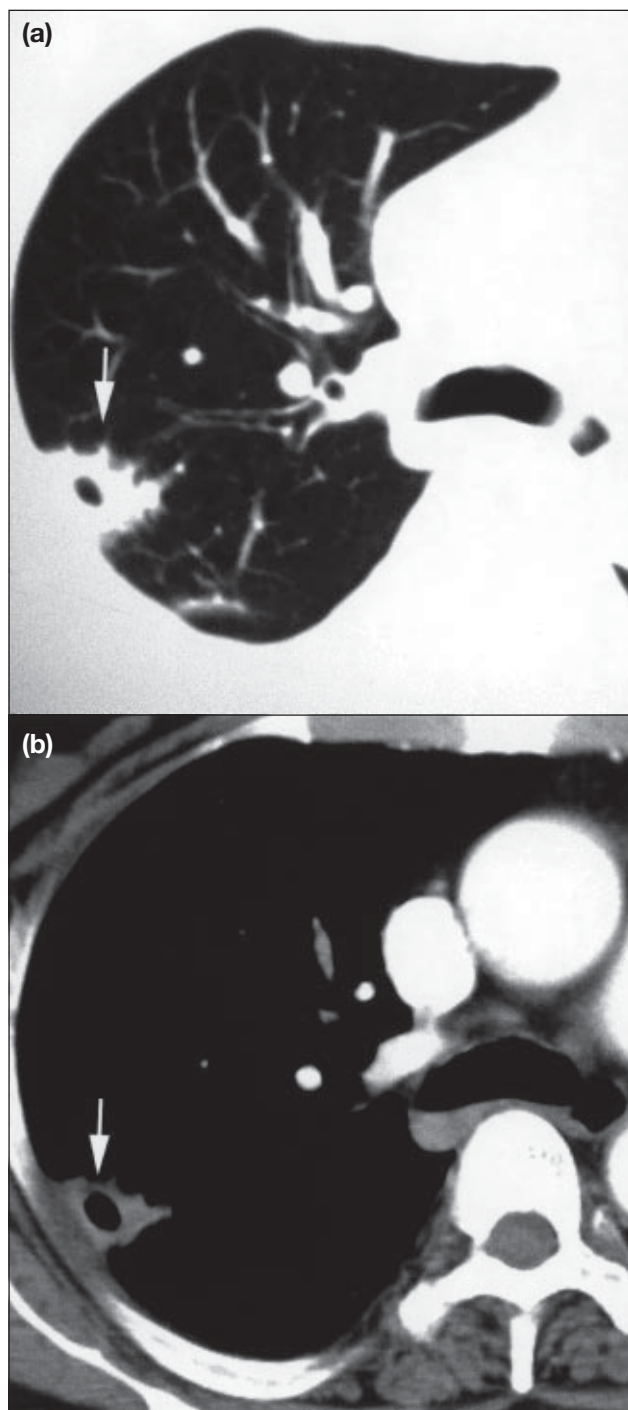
Computed tomograms showing a cavitating mycetoma
